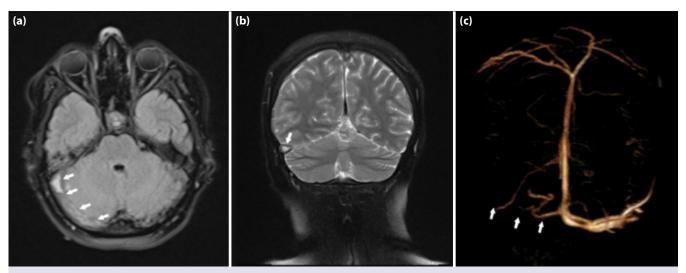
Axial FLAIR image (a) and coronal T2 weighted image (b) showing signal void loss in the right transverse sinus (arrows). (c) Loss of right transverse sinus flow on the volume-rendered Time-of-flight (TOF) MR venography image (arrows).
